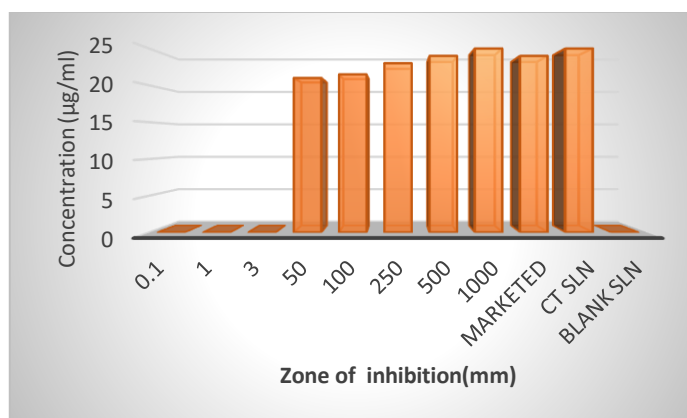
Comparative Antifungal activity of different dilutions of Co-trimoxazole with marketed and F12 CT-SLN formulation.
